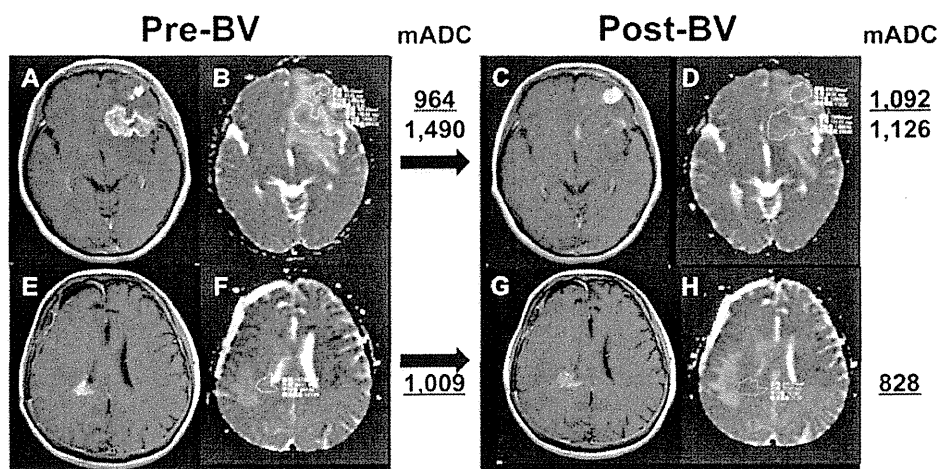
Post-contrast T1-weighted images aligned side-by-side with the corresponding ADC maps in patients with tumors which did not respond to BV (a, b, c, d: case 3; e, f, g, h: case 6). Note that the non-responding lesions have mADC values below 1100 ($10^{-6} \text{ mm}^2/\text{s}$). In case 3, the anterior frontal lesion with an initial mADC of 964
